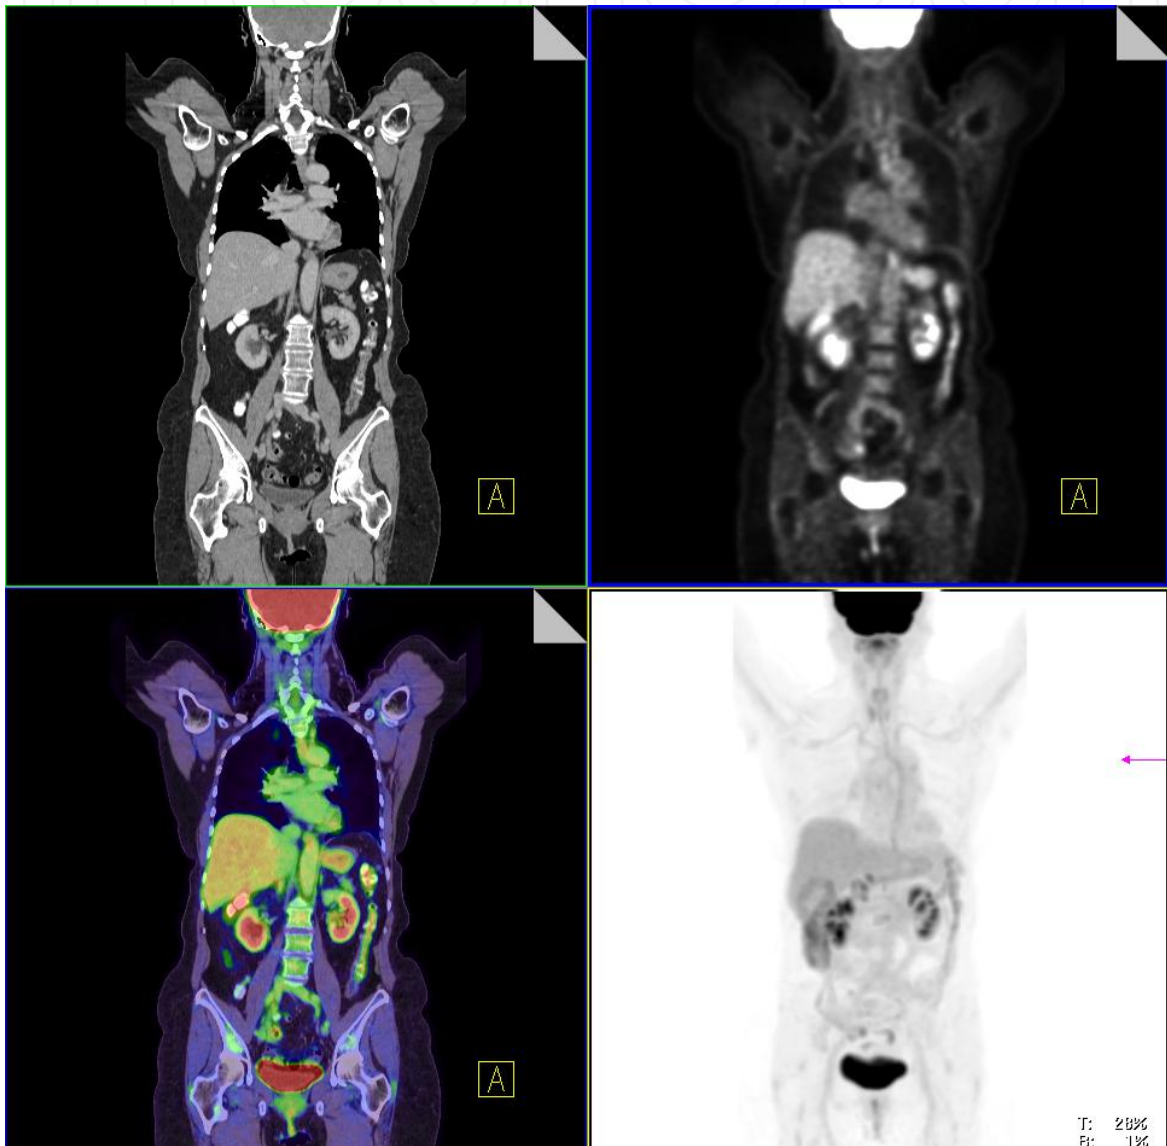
PET-CT fusion images: Images were acquired during co-registered acquisition and fused during post-processing
